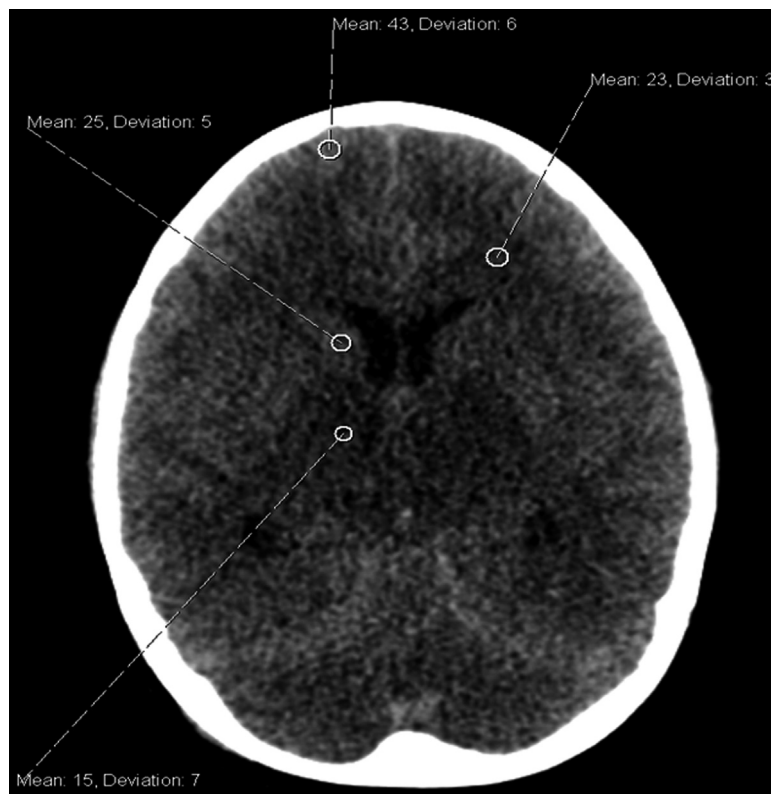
Axial non-contrast computed tomography brain image through the level of the thalami: There is symmetrical low attenuation change affecting the thalami with mild edematous swelling and compression of the third ventricle as a result. (The relative mean values [with standard deviation] of Hounsfield units of affected thalamus, unaffected head of the caudate nucleus and unaffected frontal cortical grey matter and white matter are indicated with appropriate regions of interest).
